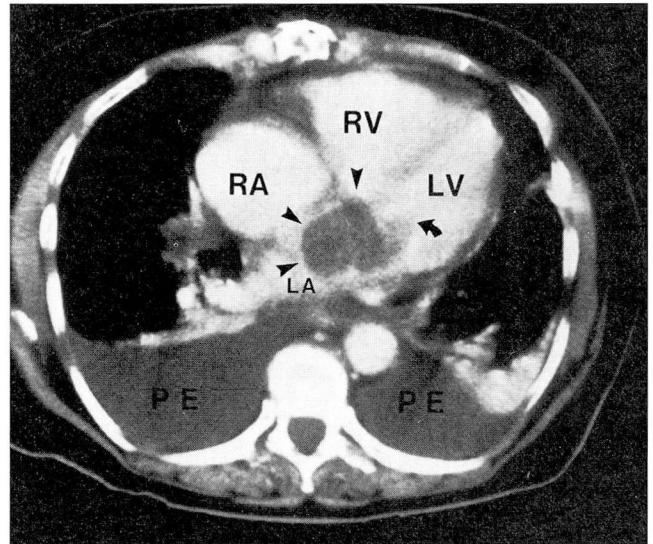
CT scan during bolus administration of intravenous contrast material, showing a 5- x 5-cm nonenhancing soft tissue lesion (arrow heads) of the left atrium extending through the mitral valve (curved arrow). Also note bilateral pleural effusions. (RA, right atrium; RV, right ventricle; LV, left ventricle; LA, left atrium; PE, pleural effusion.)
